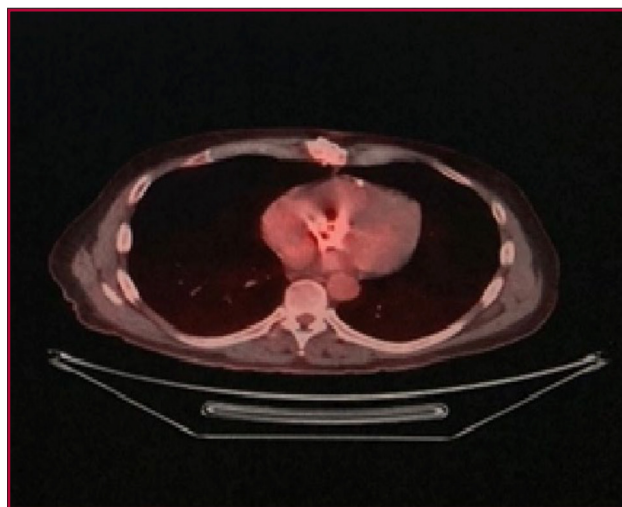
PET/CT with fluorine-18 deoxyglucose: transverse projection. Diffuse uptake in the aortic prosthesis is observed.
